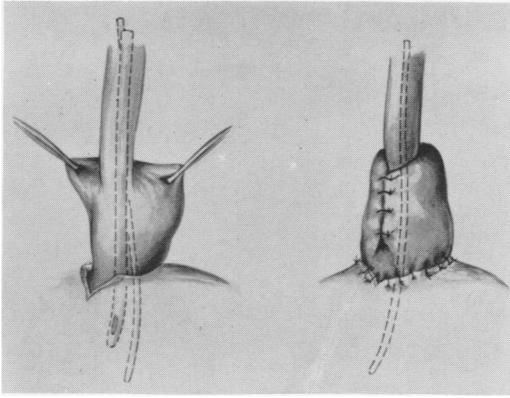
Showing the technique of fundoplication by means of the transthoracic approach. (Left) The diaphragm divided to prepare the fundic cuff. (Right) The divided or dilated hiatus is sutured circumferentially to the gastric wall.
